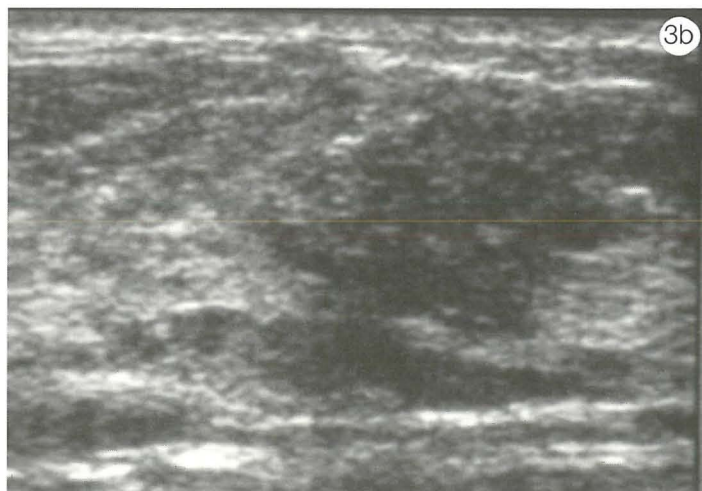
Wegener granulomatosis confirmed on core-needle biopsy. (a) Mammogram shows a suspicious focal asymmetric density (arrowheads). (b) Ultrasound image demonstrates an irregular hypoechoic mass.
